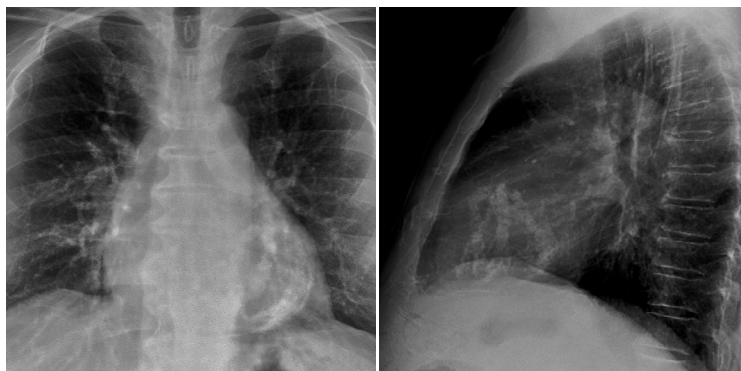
The posteroanterior (left) and lateral (right) views of patient's chest x-ray.
